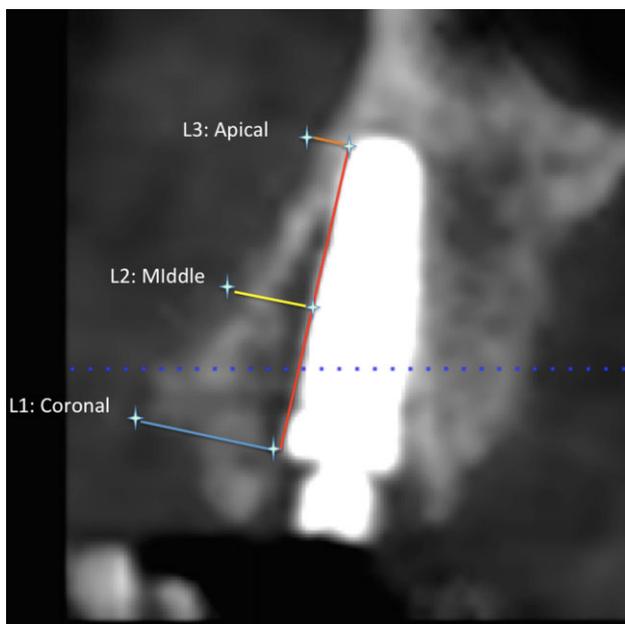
CBCT showing L1, L2, and L3, the respective reference points and the lines connecting the points providing the measurements.
